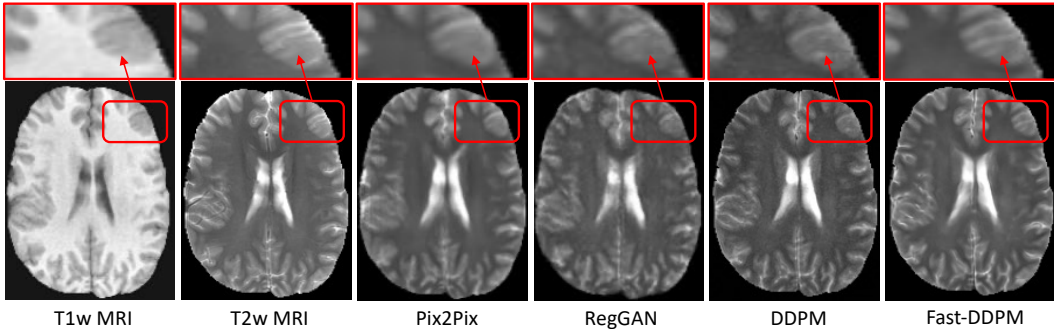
Qualitative results of the T1w MRI to T2w MRI translation task.
